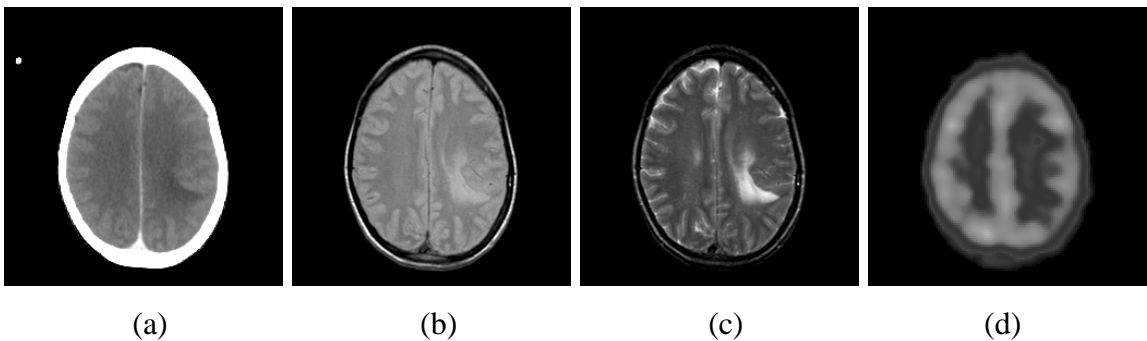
A slice of image series from one individual used in the multimodality registration experiment. (a) CT brain image. (b) MR-PD brain image. (c) MR-T2 brain image. (d) SPECT-Tc brain image.
